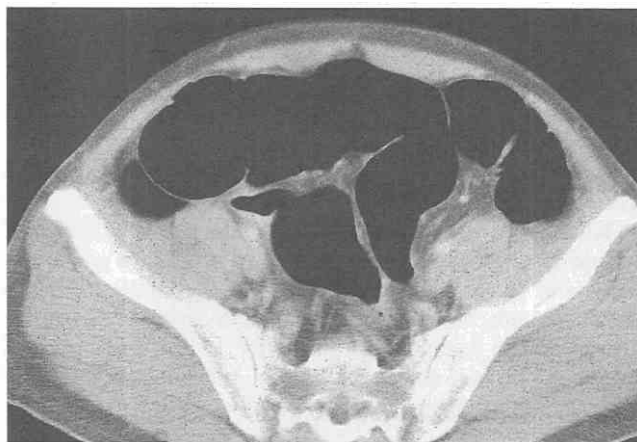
CT scan after air insufflation into the rectum.
